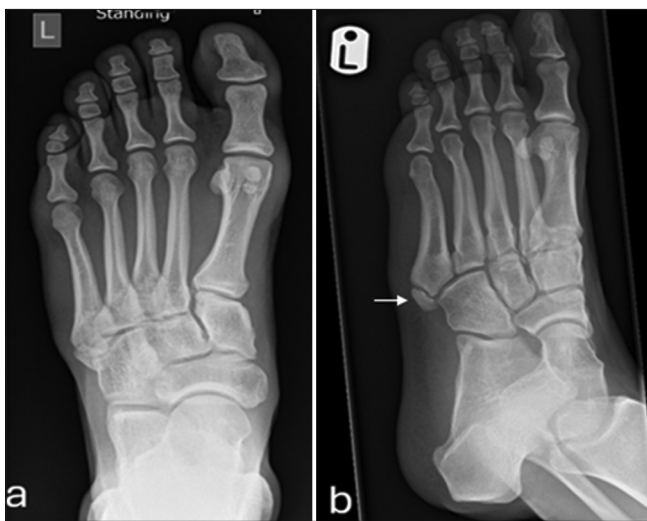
A 26-year-old footballer presented with foot pain after an injury. (a) Anteroposterior and (b) oblique radiographs showing os vesalianum pedis (white arrow).
